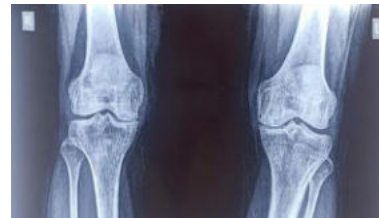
X-ray image of bilateral knees showing early osteoarthritis changes.
